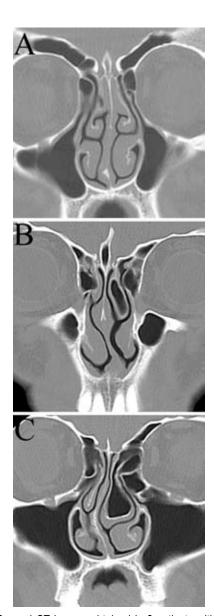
Coronal CT images obtained in 3 patients with acromegaly. A: The patient has marked hypertrophy of the nasal turbinates, with very little working space within the nasal cavity. B: There is slight deviation of the nasal septum, a left middle turbinate concha bullosa, and very restricted workspace. C: There is marked septal deviation toward the right, a large left concha bullosa, and markedly reduced workspace.
